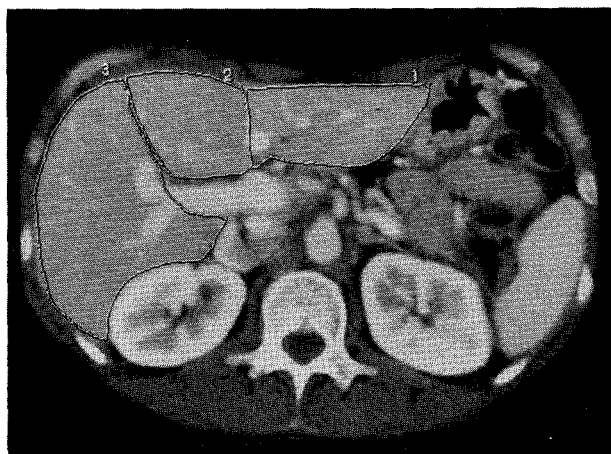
Computed tomography allowing volumetry of segments II and III, IV and right lobe (segments V to VIII).
